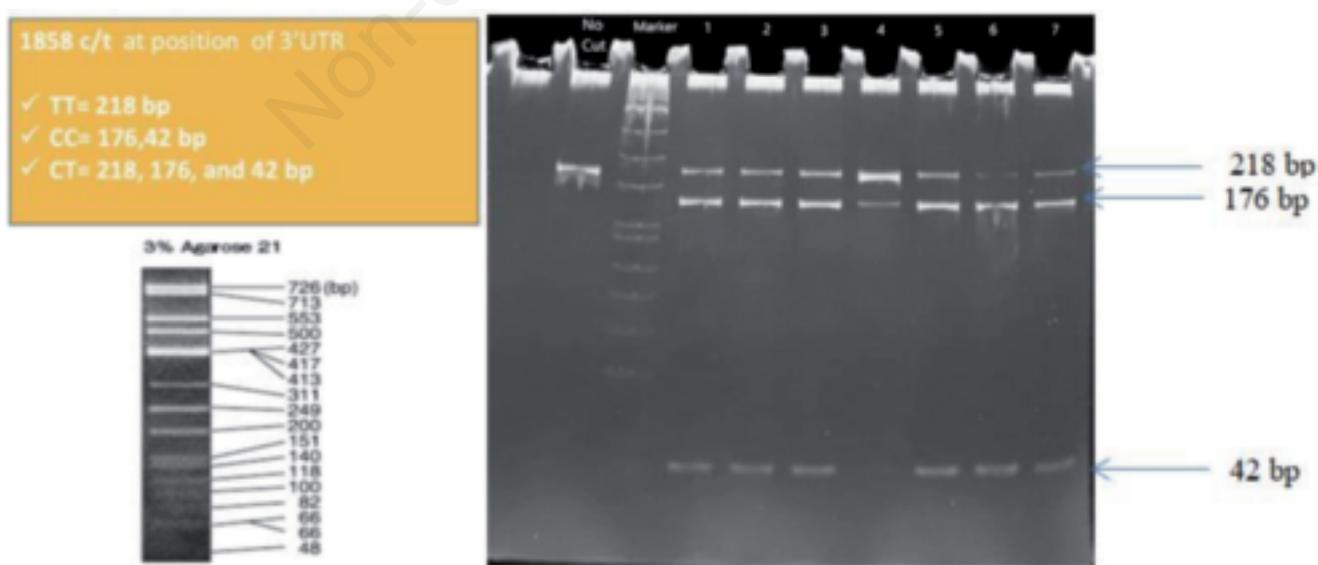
PCR-RFLP Electrophoresis result of PTPN-22 C1858T. The result of PCR-RFLP electrophoresis with enzyme restriction RsaI. The only genotype that was found in this study was CT, demonstrated in numbers one to seven. CT genotype was identified as three bands in 218, 176, and 42 base pairs.
